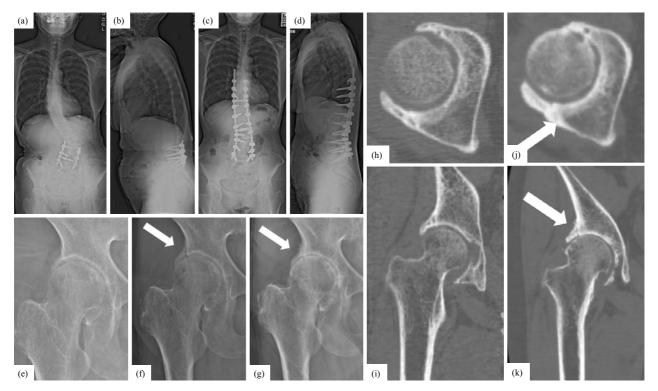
Case 2. Standing X-ray revealed a change in thoracolumbar alignment before (a, b) and after (c, d) adult spinal deformity surgery. She did not feel hip pain 4 years later (e), but her acetabular rim was fractured 5 years after adult spinal deformity surgery (f). The progression of hip osteoarthritis was confirmed radiographically 7 years after adult spinal deformity surgery (g). The acetabular rim was not fractured before adult spinal deformity surgery (h, i) but fractured after surgery. The fracture site tended to bony fusion at 7 years after adult spinal deformity surgery at axial (j) and coronal plane (k) on computed tomography.
